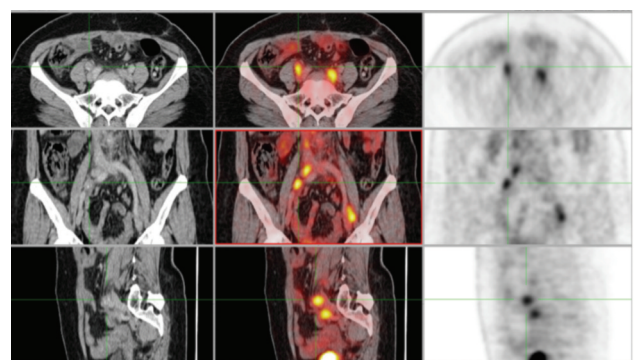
51-year-old patient. Contrast enhanced (CE)-CT detected multiple abdominal, right and left internal iliac nodes, left external iliac and left inguinal nodes (range: 11-14 mm). Most of these nodes showed active FDG uptake on PET images (SUV_{max} range: 4.2-10.9).
